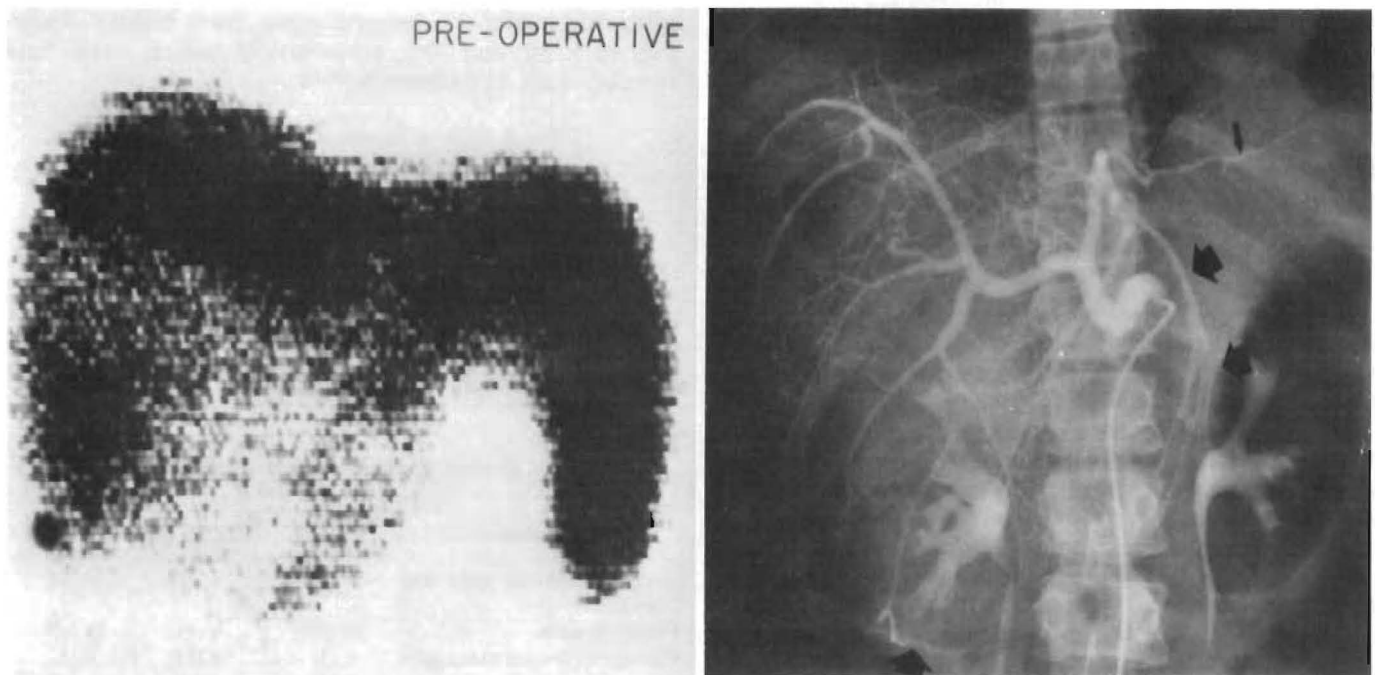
Preoperative radiographic studies. *Left*, 99m technetium liver scan (anteroposterior projection) showing a very large filling defect. *Right*, selective common hepatic arteriogram. *Broad arrows* indicate the extent of the tumor as outlined by the abnormal configuration of vessels. *Thin arrow* points to the dorsolateral branch of the left hepatic artery. This vessel, supplying the lateral segment of the left lobe, was the only hepatic arterial branch preserved. (By permission of *American Journal of Surgery* 129:587-590, 1975.)
